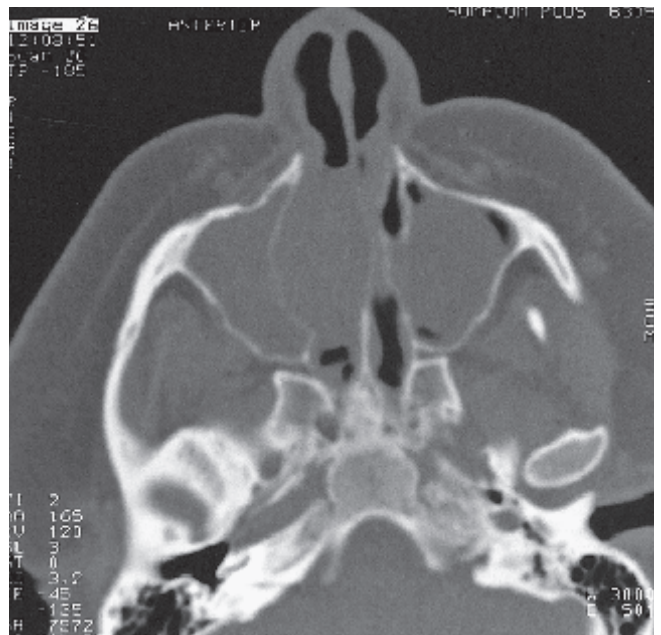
Axial CT-scan at the level of the lesion.
